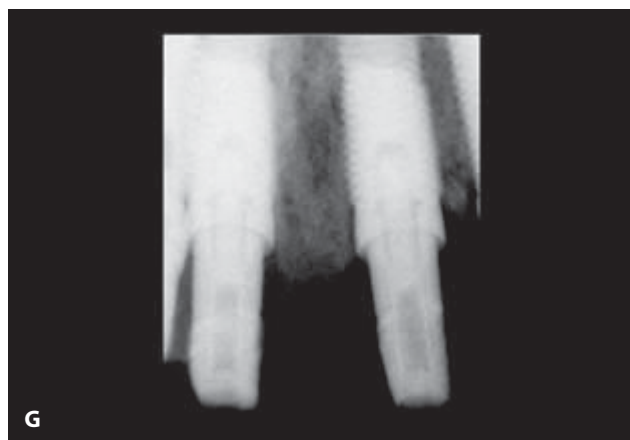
Radiographic view showing the bone levels maintained between implants when platform switching is used.
